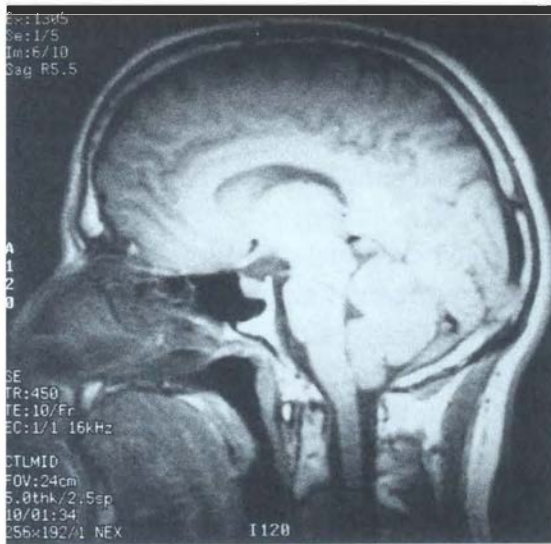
Magnetic resonance imaging (MRI) can be used to generate anatomical images of striking clarity and beauty; this image simply demonstrates normal brain anatomy. The patient is facing to the left, with the nose faintly visible and the nasal membranes apparent behind the nose. The cerebral hemispheres fill most of the volume of the skull, with the furrows (sulci) clearly visible. The spinal cord is seen entering the picture from the bottom right, where it widens to form the medulla oblongata. The cerebellum is visible near the base of the skull, beneath the posterior portion of the cerebrum. (Photograph courtesy of Dr. Kenneth Maravilla and Dr. James A. Nelson, University of Washington School of Medicine.)
